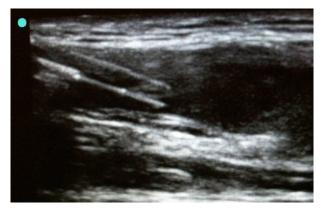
Sonographic image with the transducer turned for an in-plane technique. The catheter can be observed as it is threaded off the needle into the vessel.
